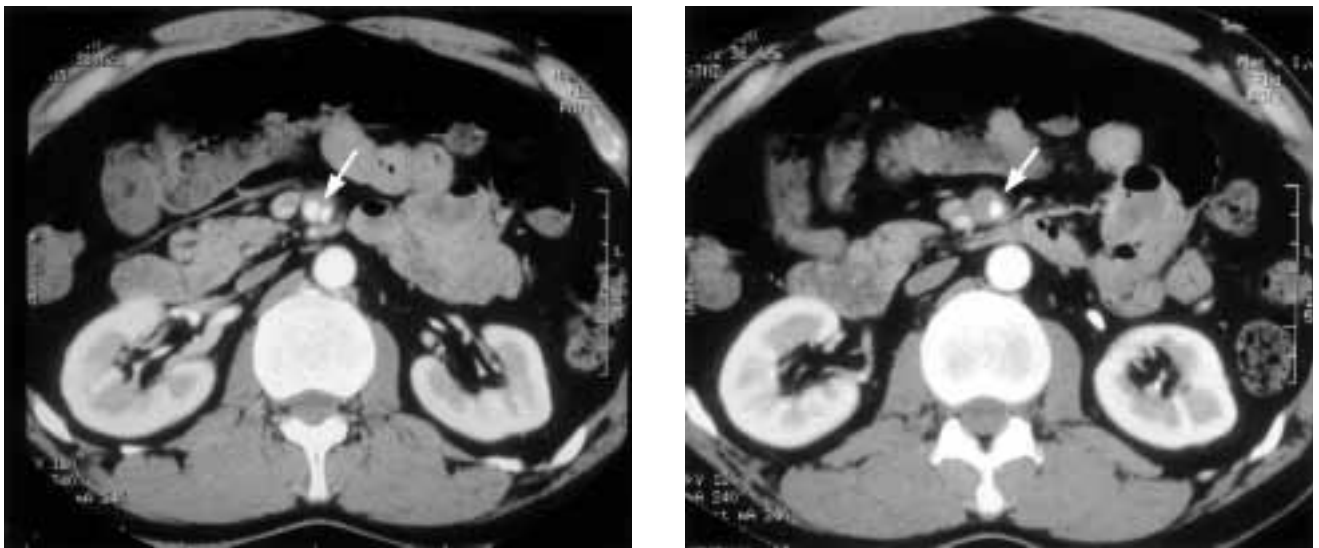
Abdominal CT scans revealed an intimal flap separating the true and false lumens of the SMA 3 cm from its origin (a) as well as thrombosis in the peripheral false lumen (b).
